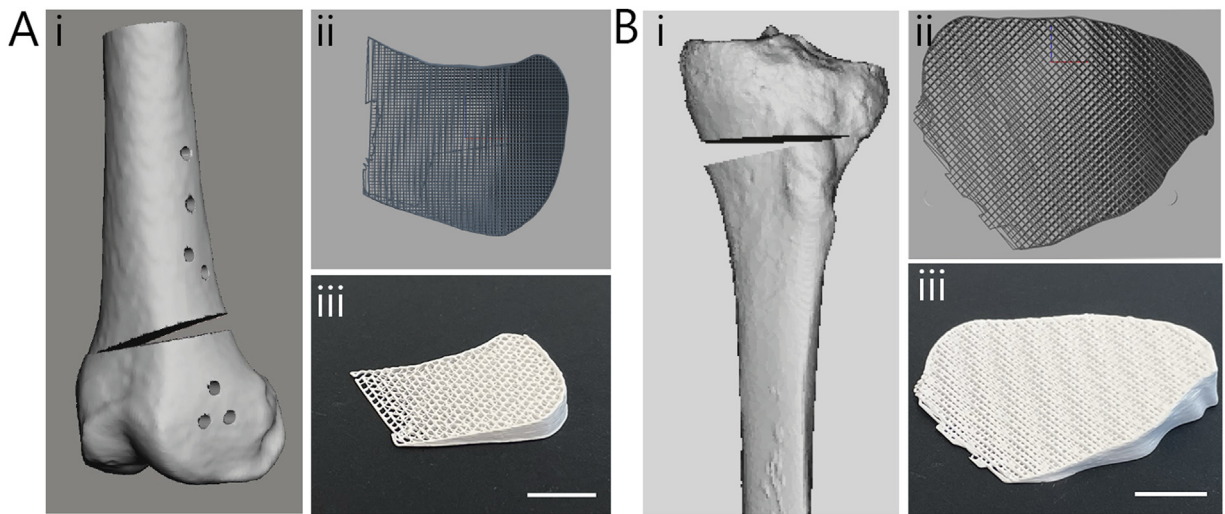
Surgical planning and extrusion-based printing. Wedge design for open-wedge osteotomies in distal femur (A) and proximal tibia (B). Panels i, Surgical planning of open-wedge osteotomies derived from computed tomography scans. Panels ii, Top views of printing paths of computer-aided designs of personalized wedge implants. Panels iii, The finalized personalized wedges in magnesium strontium phosphate-polycaprolactone biomaterial. Scale bar = 10 mm.
